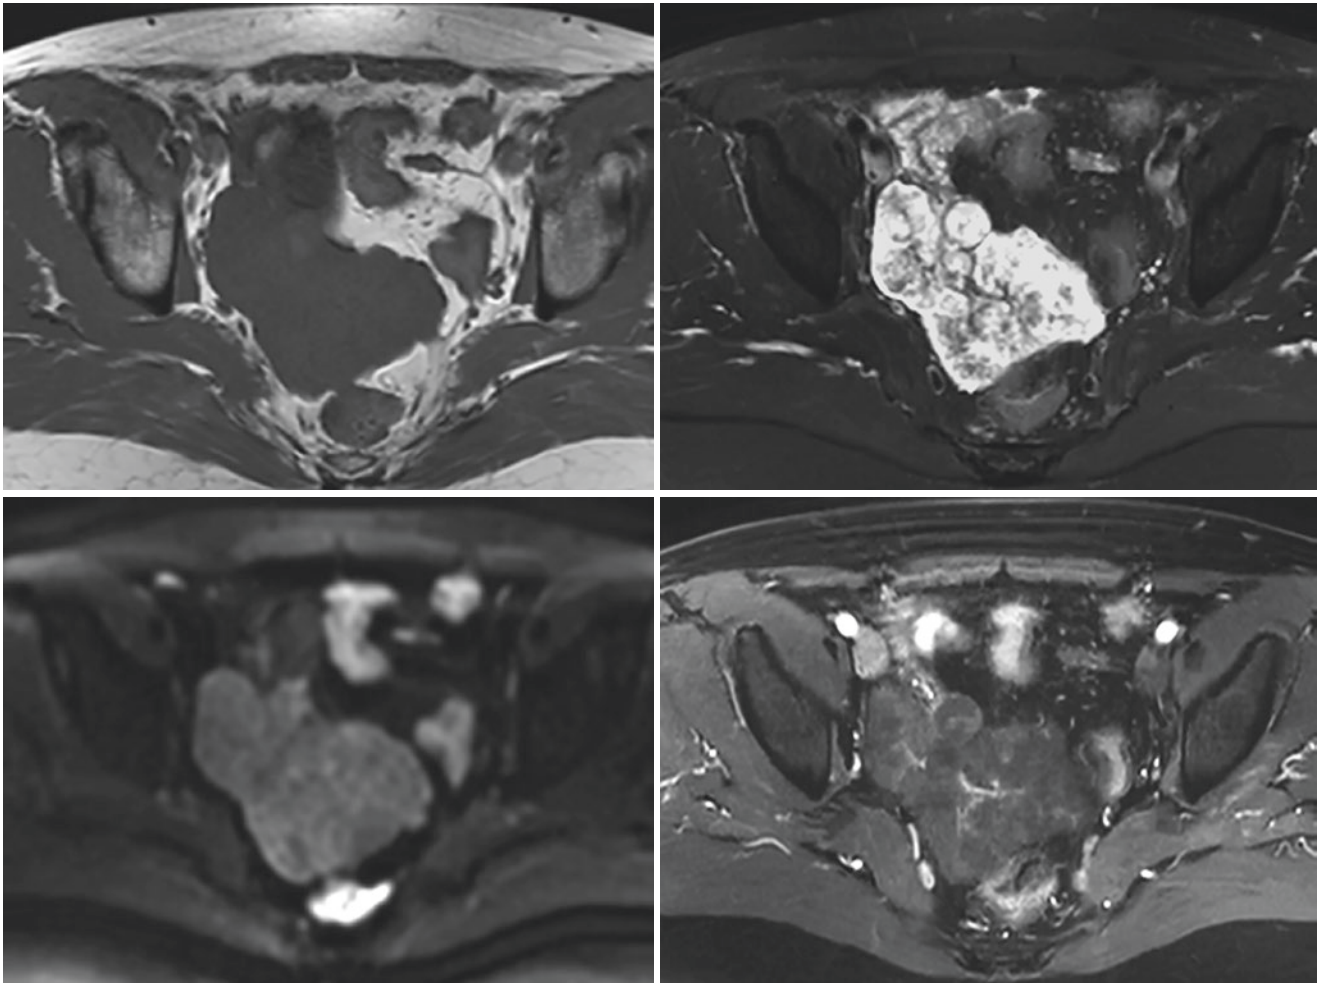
A 55-year-old woman with right ovarian borderline serous tumor. Axial T1-weighted image (a) showed an ovarian lesion of low signal intensity. T2-weighted with fat suppression image (b) showed the lesion had high signal intensity. Internal branching fibrous stalks
